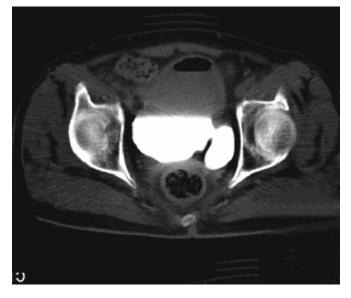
A computed tomography (CT) scan shows a large bladder diverticulum on the left inferolateral wall
